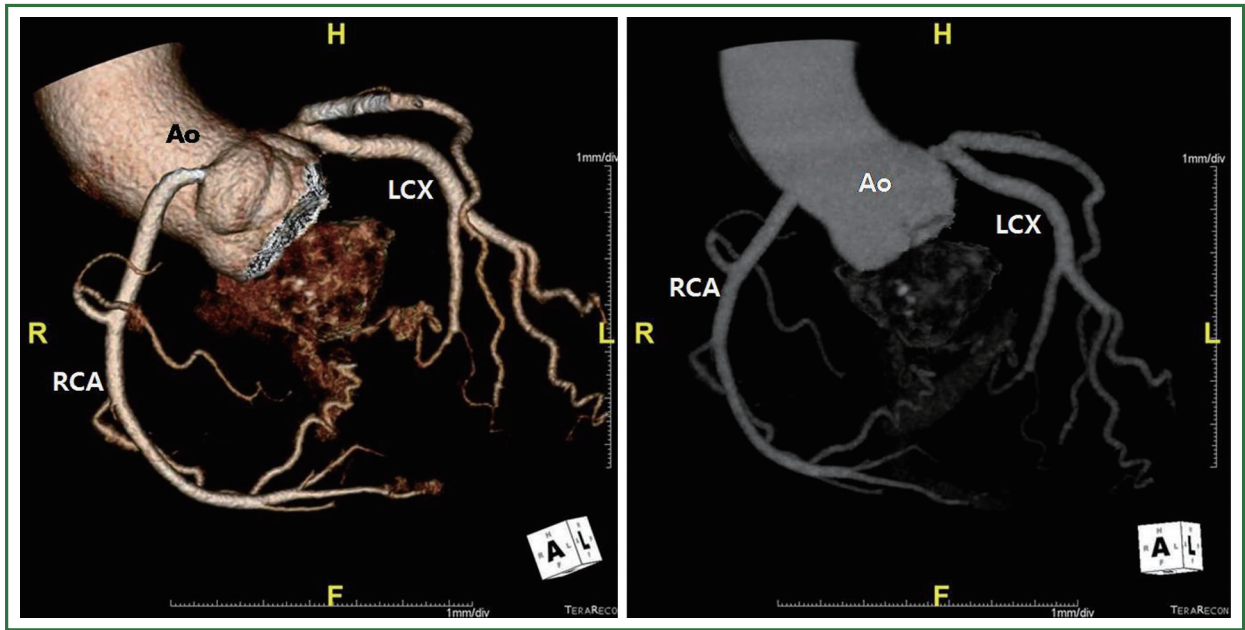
Coronary CT angiogram showed heterogeneous enhanced mass. Abbreviations: Ao, aorta; LCX, left circumflex artery; RCA, right coronary artery.
